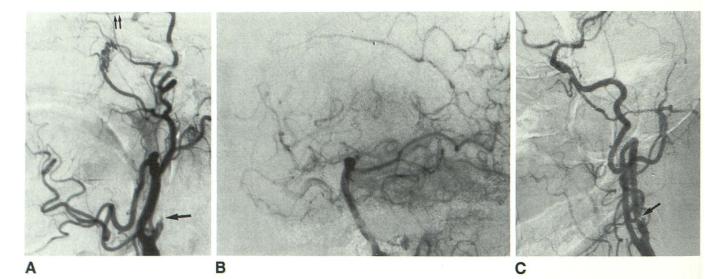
Case 1: 54-year-old man with recurrent transient right brachial monoplegia and speech disorder. First episode occurred 3 weeks earlier. Complete neurologic recovery between episodes. CT was normal (see Fig. 1A).
